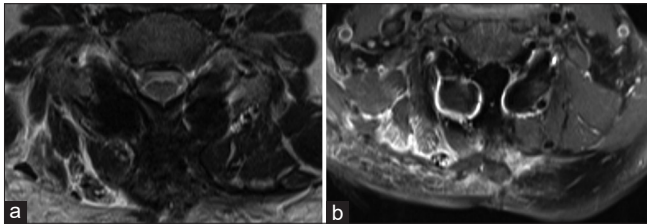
Axial T2-weighted (a) and contrast-enhanced axial T1-weighted (b) magnetic resonance imaging of the neck showing tumor mass (red asterisk) anatomically located between the trapezius muscle and the splenius capitis muscle. Metal-related artifacts in MRI (b) caused by lateral mass screws (white arrow).
